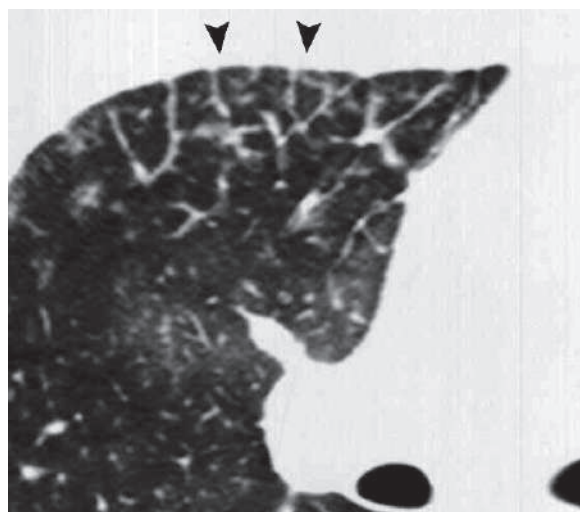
Axial lung window HRCT in a patient with TB shows peripheral tree-in-bud appearance (*arrowheads*)
